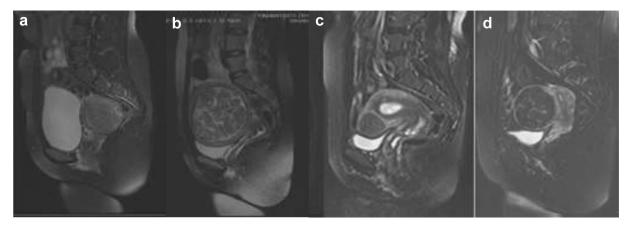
T2-weighted magnetic resonance images obtained before treatment: (a) homogeneous hyper-intense fibroid; (b) heterogeneous hyper-intense fibroid; (c) iso-intense fibroid; (d) hypo-intense fibroid.
